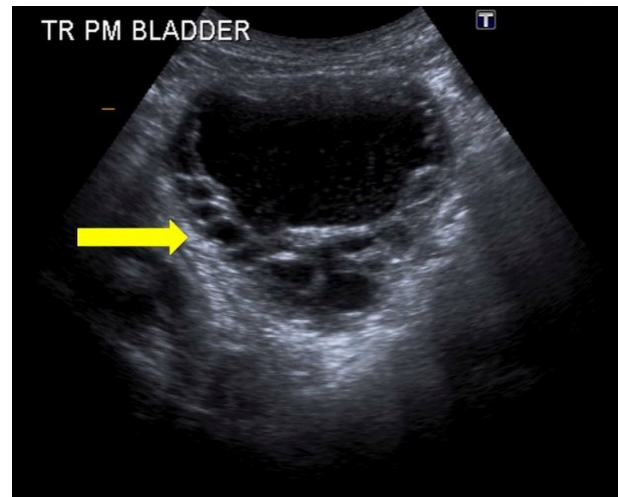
Ultrasound bladder. Arrow highlighting cystic changes.
